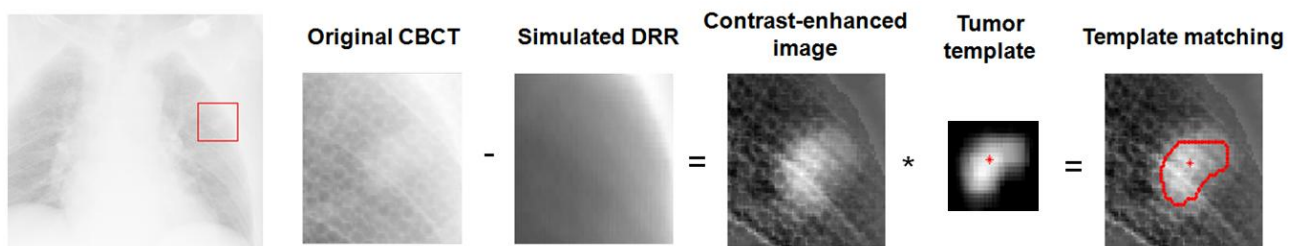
Application of the developed contrast enhancement and template matching technique to an exemplificative cone-beam projection. The circular structures visible in the original CBCT image come from the stereotactic body frame applied for patient's immobilization.
